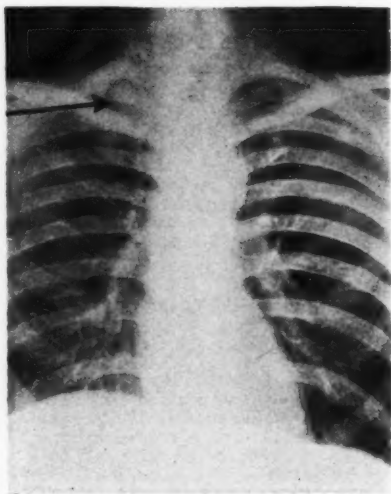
Radiograph of chest with arrow indicating an early infiltration in the right apex above the first rib. There is also some thickening of the ascending branches on the left side with increased density in the hilar regions.
